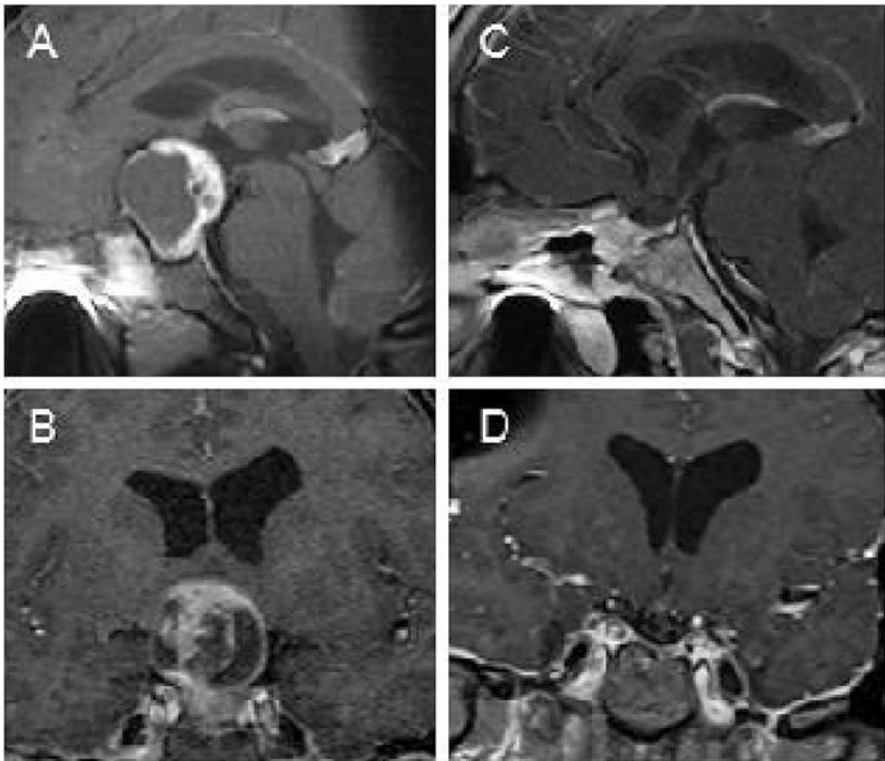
GH-secreting macroadenoma (a, b) Sagittal and coronal postcontrast imaging demonstrating a GH-secreting macroadenoma with suprasellar extension in a five-year-old girl who presented with gigantism. (c, d) Sagittal and coronal postcontrast MRI 1 y after undergoing successful adenectomy with endoscopic endonasal transsphenoidal surgery
